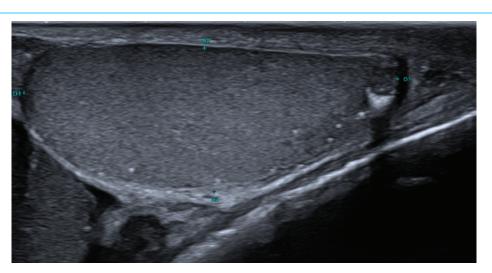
Right testicular ultrasound showing multiple microlithiasis, right testis hypothrophy and a macro-calcification (6 mm).
